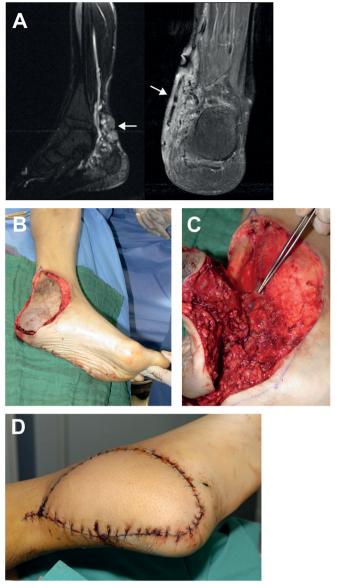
A 26-year old patient suffering from an AVM of the medial ankle. Prior to presenting in our institution the patient had been embolized three times (6, 5, and 3 years before surgery), but no significant reduction of size and symptoms had been achieved. Further embolization had been deemed unfeasible and thus no preoperative embolotherapy was undertaken; (A) preoperative MRI, (B) intraoperative aspect of the AVM, skin alterations due clearly visible, (C) feeding vessels exposed before complete excision, (D) postoperative aspect of antero lateral thigh (ALT) flap.
